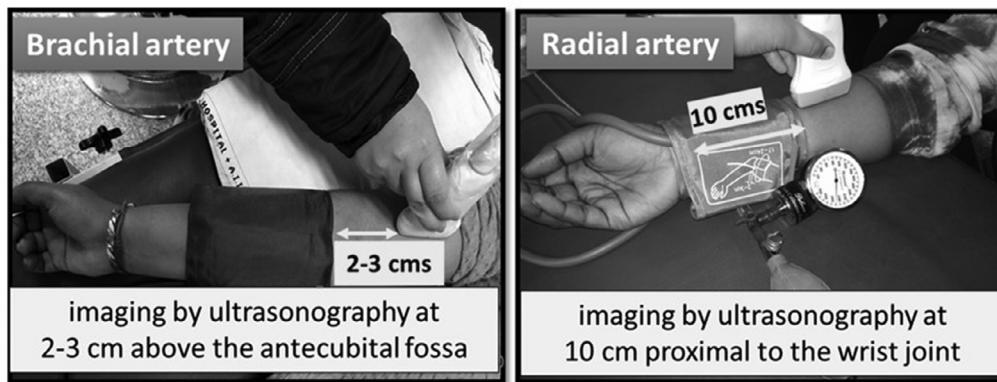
The anatomy required for obtaining B-mode ultrasound images of brachial and radial artery. The figure also shows the position of the occluding cuffs used to produce distal circulatory arrest.
